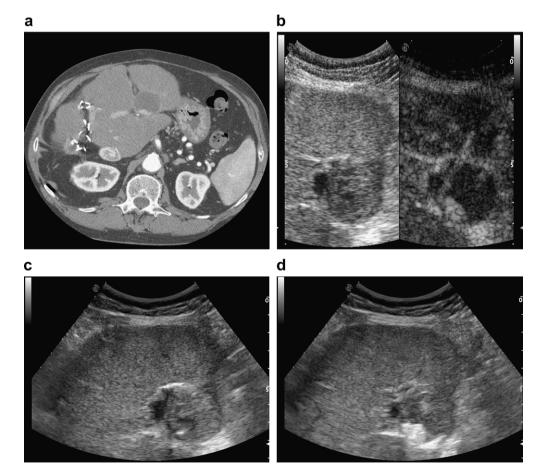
Percutaneous ablation of HCC. Multidetector CT image acquired after RF ablation shows small focus of residual, arterially enhancing viable tumour (a). Contrast-enhanced US clearly shows the area of residual disease as clear-cut enhancing nodule within the non-enhancing coagulated tumour (b). Precise real-time needle targeting of the tiny area of residual disease is easily achieved (c) and additional treatment with ethanol injection is administered (d).
